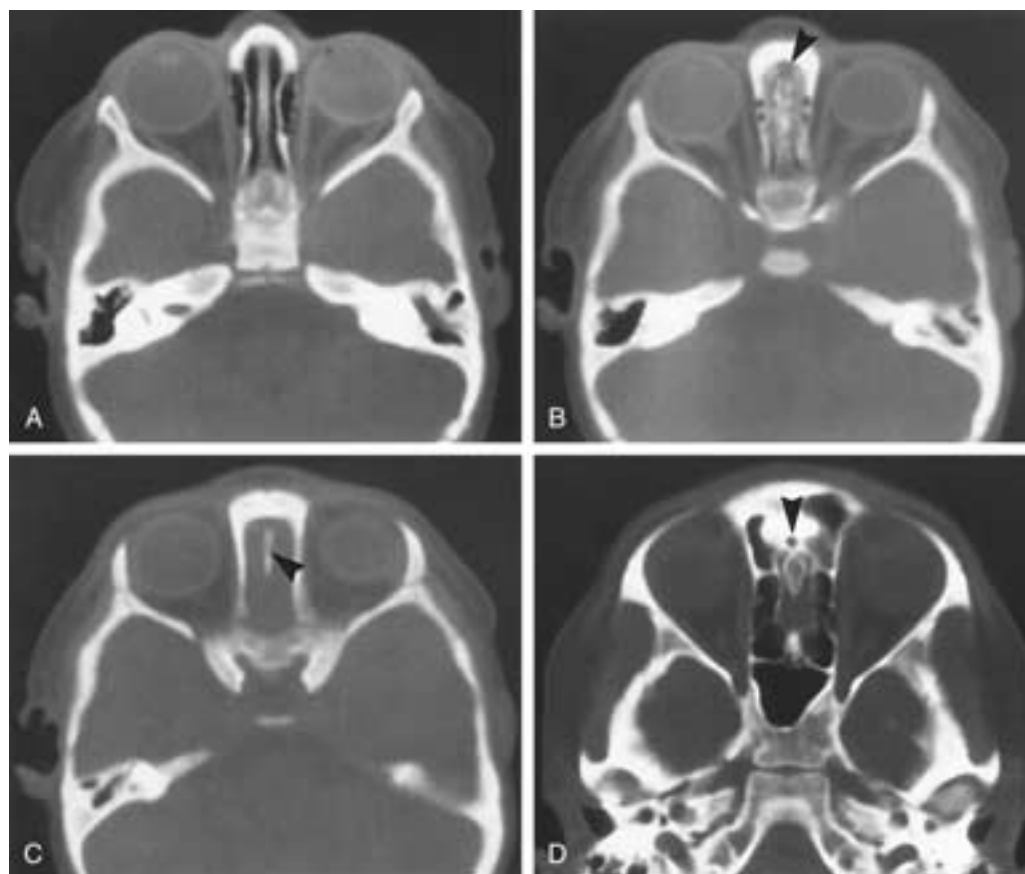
Normal pattern of ossification as shown on axial noncontrast CT. In the 11-month-old girl shown in A to C, serial axial images display the following: (A) The normal, thin nasal septum with faint parallel ossifications representing the vomer, (B) the normal midline defect (*black arrowhead*) anterior to the normal parallel ossification within the closing cribriform plates and crista, and (C) the upper portion of the crista (*arrowhead*) with a small fossa anterior to it. Comparing these images with the coronal sections in Figures 1-6 through 1-8 aids understanding of how the parallel ossifications arise. D, Twelve-year-old boy. The foramen cecum (*black arrowhead*) is a well-defined ostium situated just anterior to the diamond shaped ossified crista galli.
